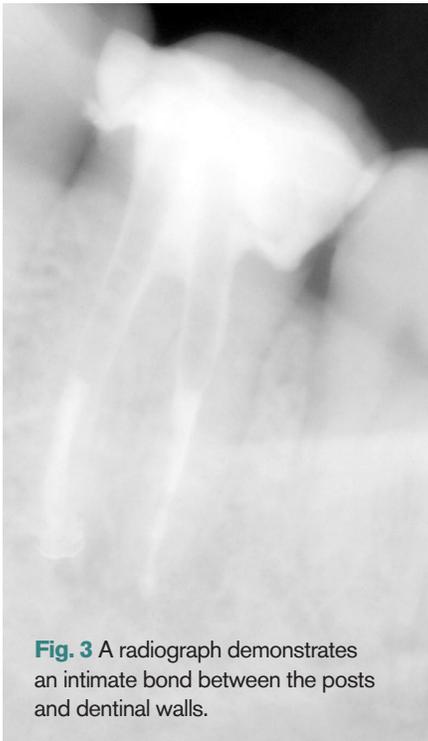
A radiograph demonstrates an intimate bond between the posts and dentinal walls.
